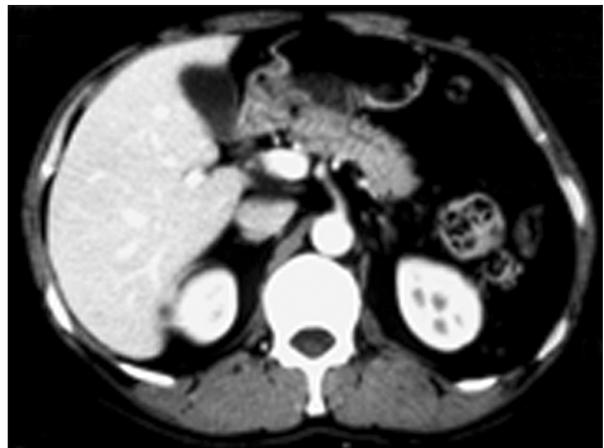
Follow-up computed tomography scan 7 months later shows resolution of the mass in the pancreatic head.
